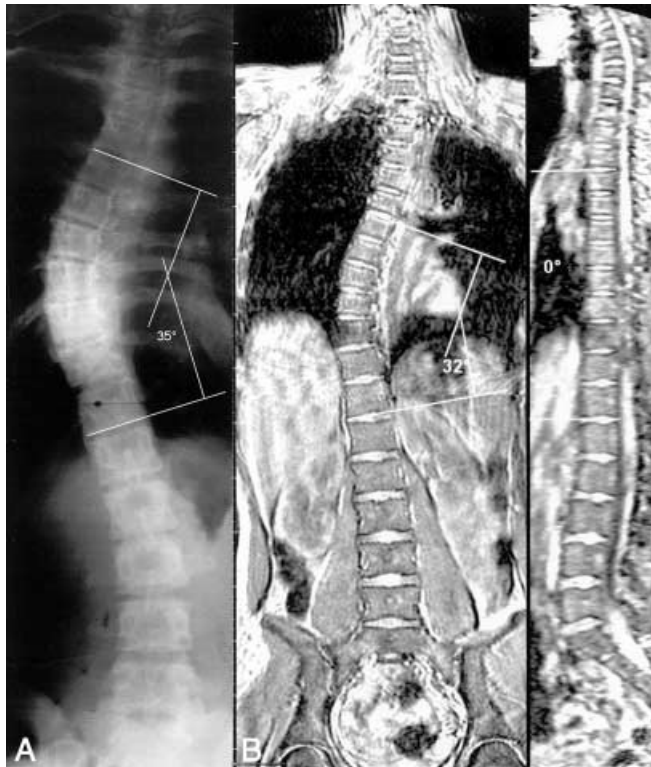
A 15-year-old girl with right thoracic scoliosis and brace treatment. A Conventional radiograph with a coronal Cobb angle of 35° . B Magnetic resonance (MR) total spine imaging with a coronal Cobb angle of 32° . In the sagittal plane the thoracic lordosis is shown with a sagittal Cobb angle (T4–T12) of 0°
